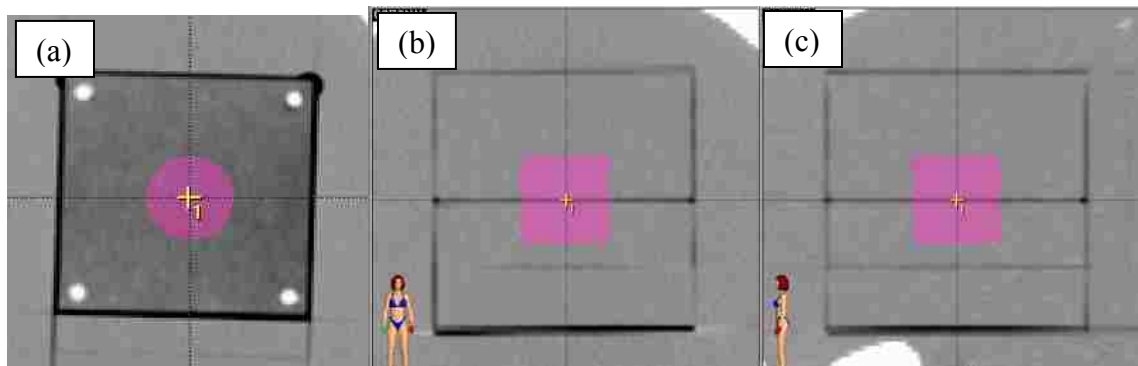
Cylindrical PTV views (2 cm diameter x 2 cm height) for axial CT data set. (a) Axial plane (contains film) (b) Coronal plane (c) Sagittal plane
